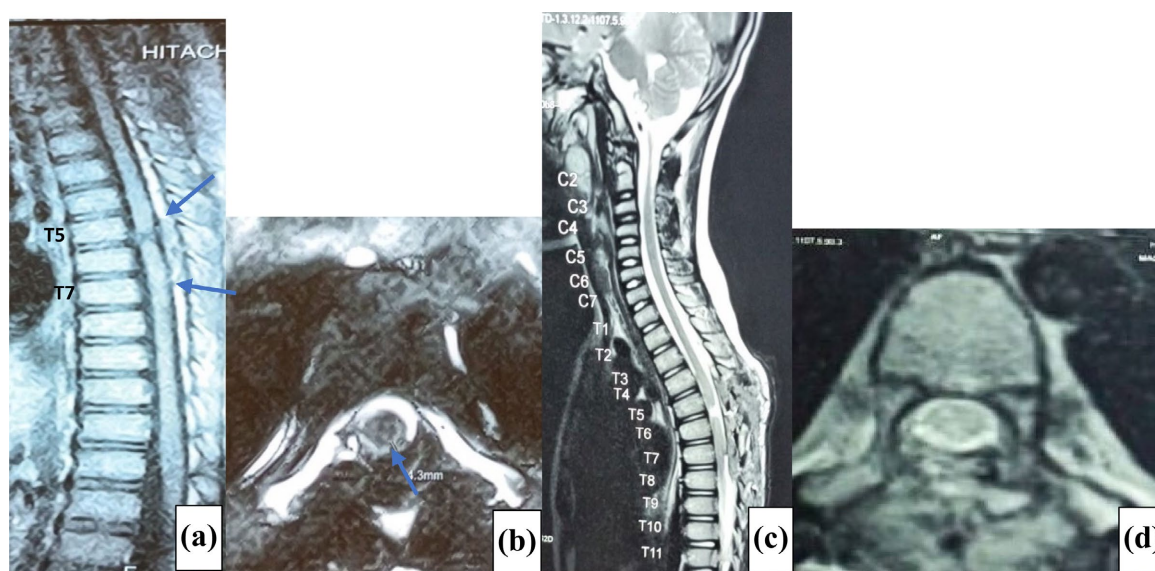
(a), (b) MRI sagittal and axial view showing an intradural extramedullary mass from T5-T7 level surrounding by edema and measuring 24.8×10 mm (blue arrow). (c), (d) Postoperative view showing a complete excision of the mass (sagittal and axial view).
